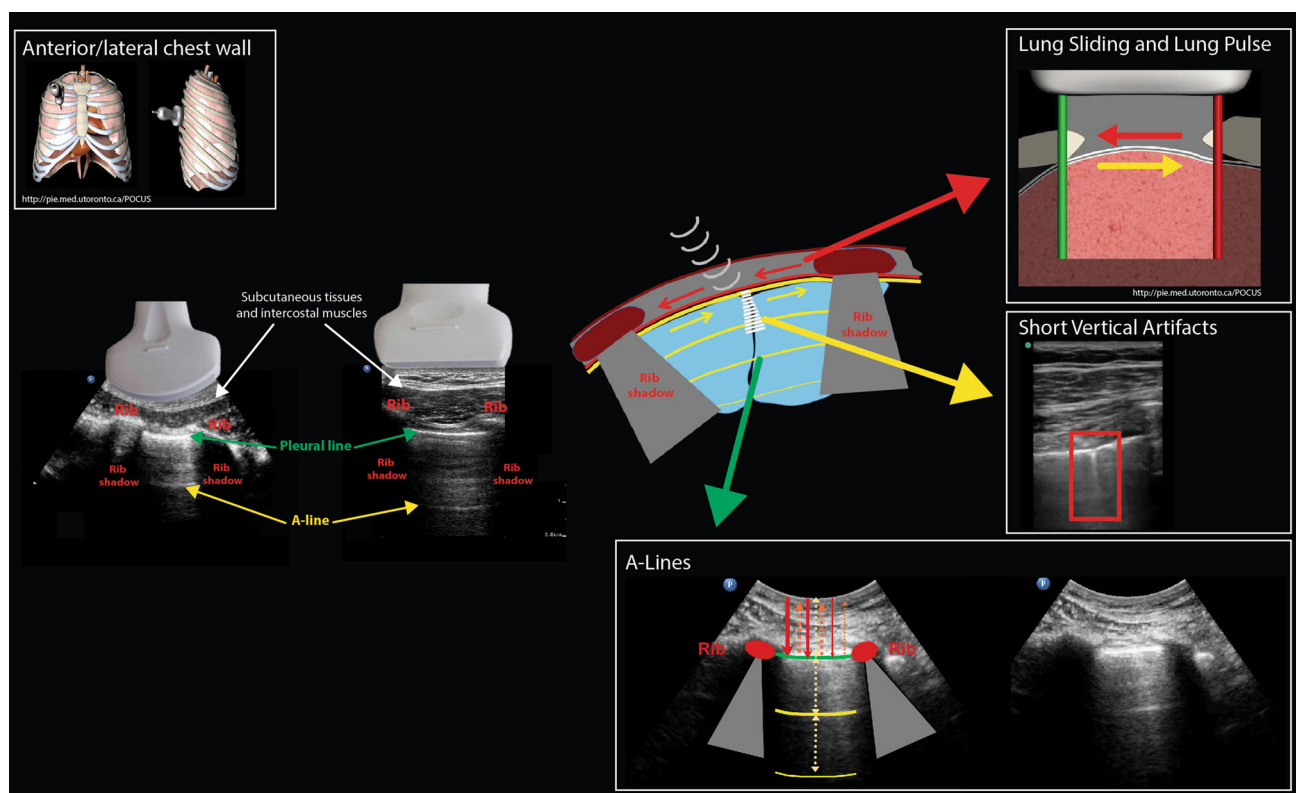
Normal lung ultrasound findings: anterior and lateral chest. In normal lungs, when a transducer is placed sagittally on the chest wall over any intercostal space projecting over aerated lung (e.g., 2nd to 7th), the following structures and artifacts may be identified: 1) subcutaneous tissues and intercostal muscles; 2) ribs with posterior acoustic shadowing; 3) hyperechoic horizontal pleural line at the interface between pleura and aerated lung tissue; 4) hyperechoic horizontal A line artifacts below the pleural line at multiples of the distance between the probe and the pleural line; 5) short vertical
